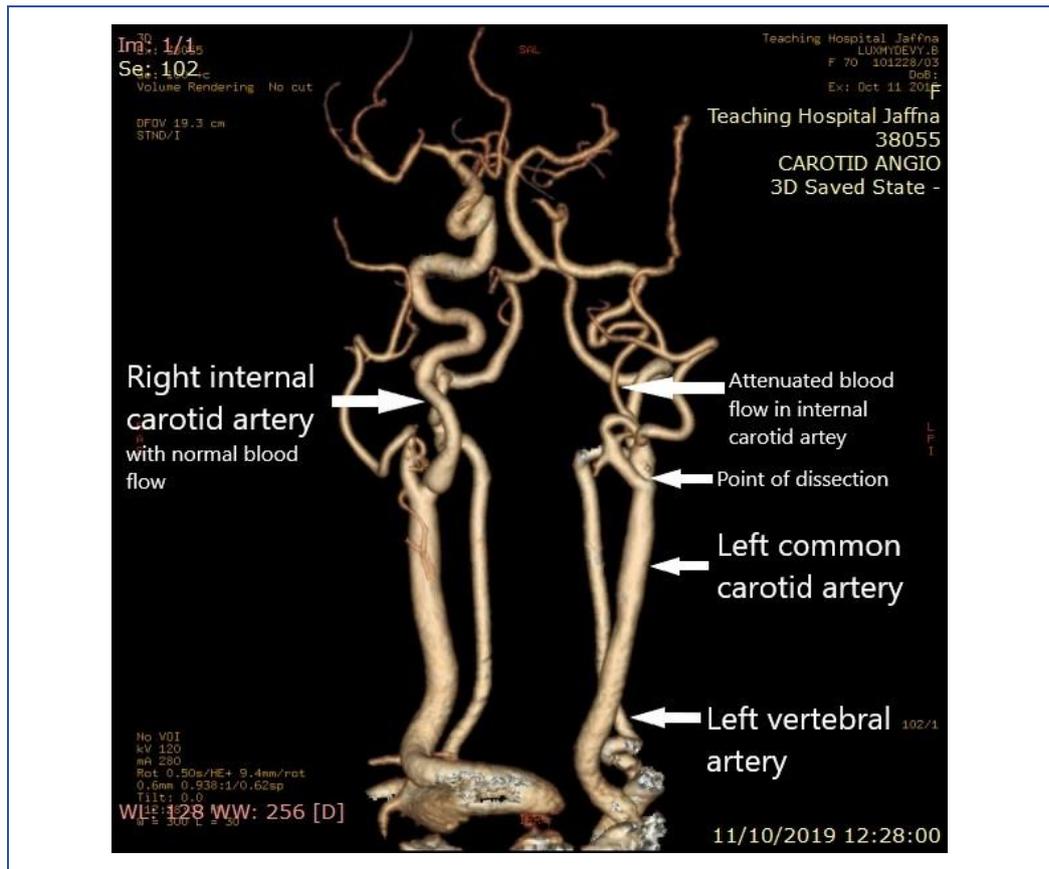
CTA showing dissection of the left ICA originating from the bifurcation of the left common carotid artery with attenuation of blood flow. There was no blood flow in the distal cavernous part of the left ICA and in the left middle cerebral artery.
